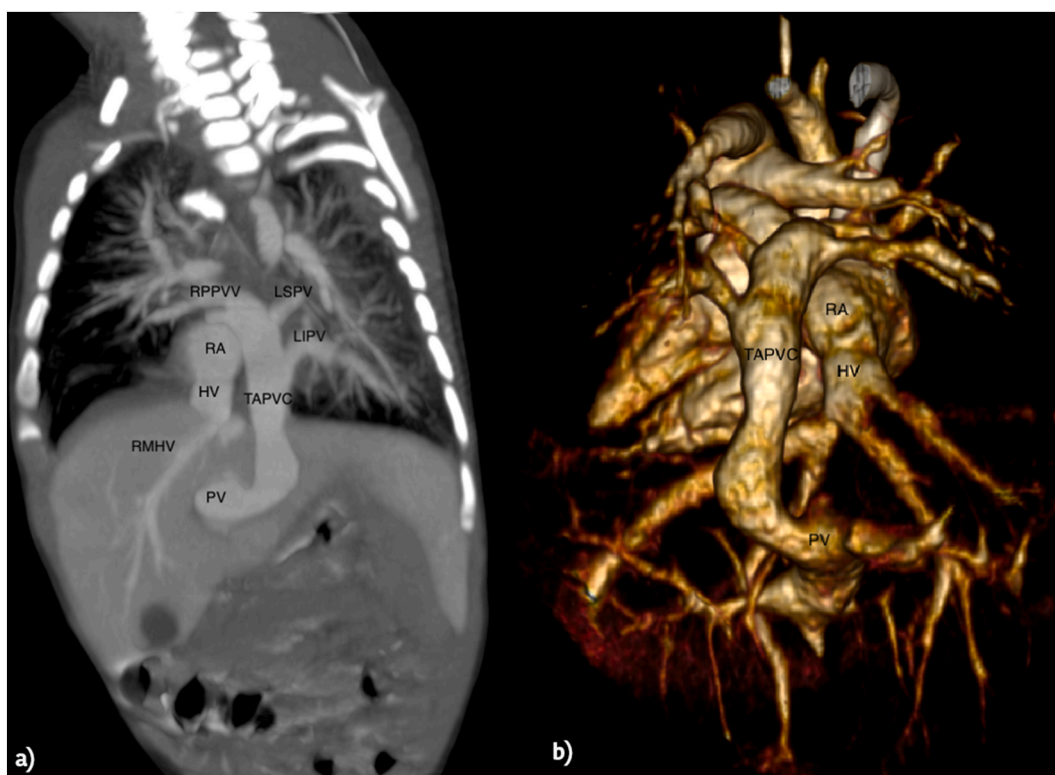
Contrast-enhanced computed tomography para-sagittal MPR (a) and VR reconstruction (b) of type III TAPVC draining in portal vein via an duct crossing diaphragm in a complex CHD. CS = Coronary sinus; HV= Hepatic vein; RA = Right atrium; RMHV = Right medium hepatic vein; TAPVC = Total anomalous pulmonary venous connection duct; LSPV = Left superior pulmonary vein; LIPV = Left inferior pulmonary vein; RPPVV = Right pulmonary veins; PV = Portal vein.
